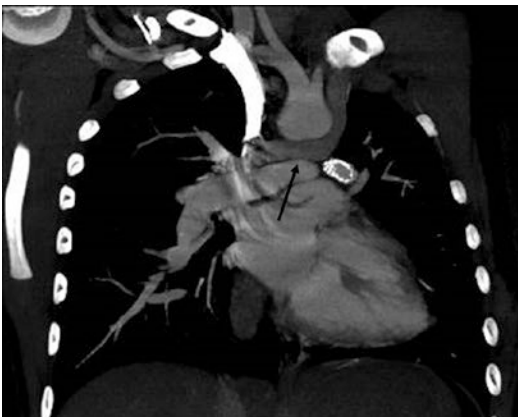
Retroaortic left brachiocephalic vein at CT angiography. Coronal maximum intensity projection image demonstrates the left brachiocephalic vein (*black arrow*) projective under the aortic arch
